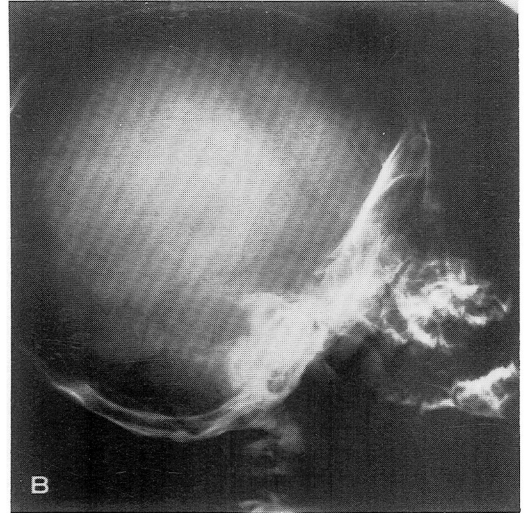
Patient 2. Lateral roentgenogram demonstrates strikingly similar features to patient 1. Note the small, maldeveloped sella turcica and shallow orbits. Very small frontal bones and anterior cranial fossa are present.
